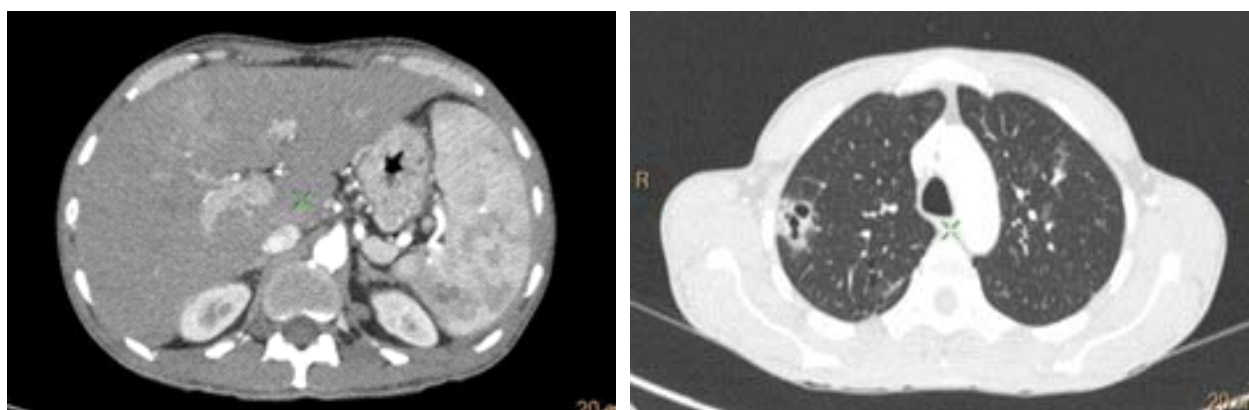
Contrast enhanced CT scan of chest and abdomen showing multiple abscesses in the lungs, liver and spleen.
